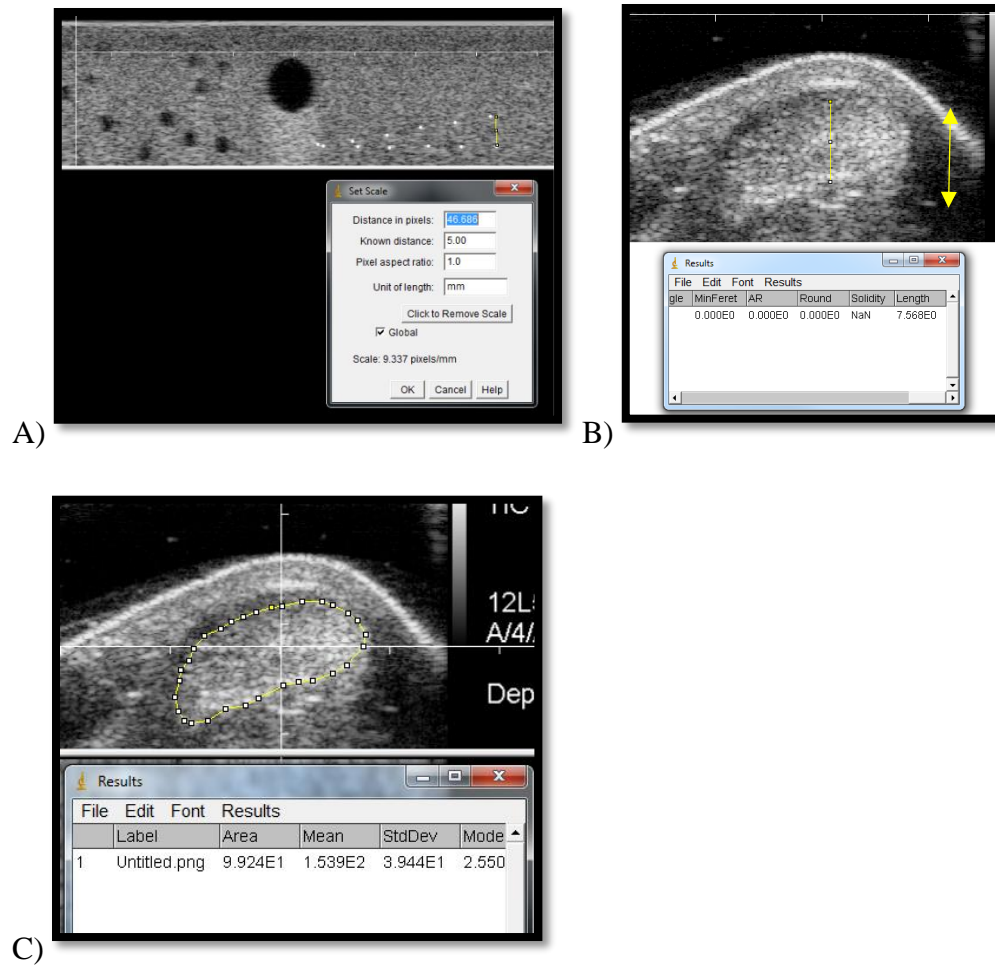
Ultrasound Distance Calibration.
